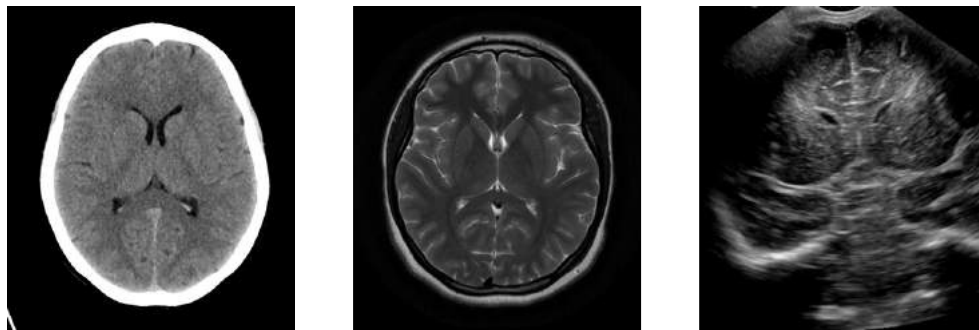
Examples of imaging of normal brain anatomy: CT (left), MRI (center), US (right).
